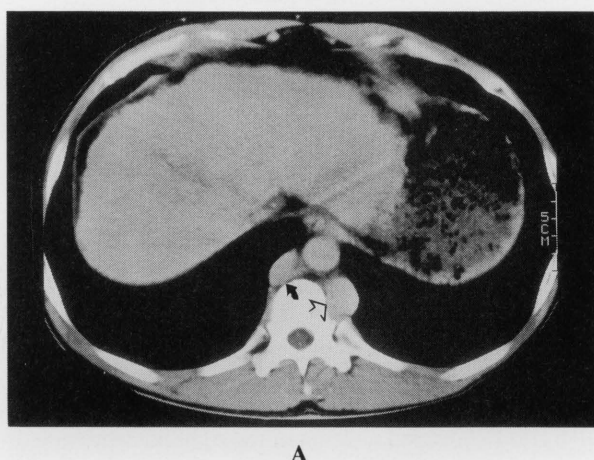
Computed tomography. A: Above the hepatic portion. The surface of the liver is serrated. No IVC is visualized, and dilated azygos (arrow) and hemiazygos veins (open arrow) are noted. B: Below the hepatic portion. Marked dilated splenic vein (arrow) is noted. IVC (open arrow) is shown beside the aorta.
